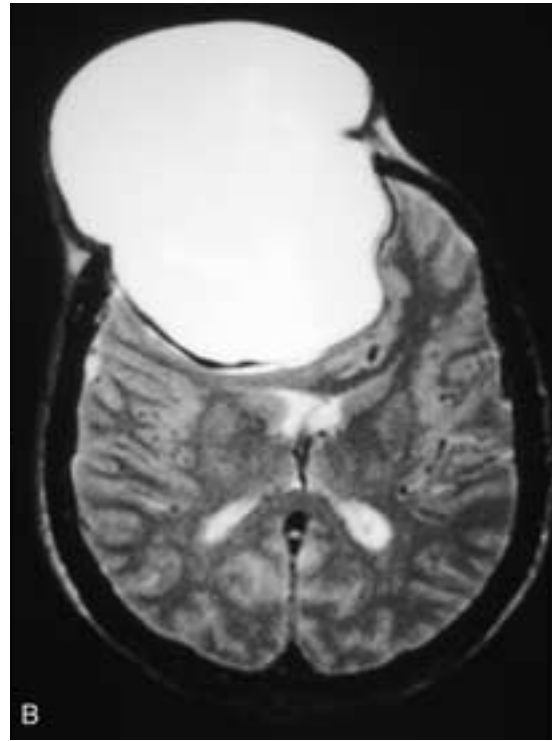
Sagittal T1-weighted (A) and axial T2-weighted (B) MR images show a huge expansile frontal sinus mass. There was no hemorrhage within this mucocele; the high signal intensity was due to the macromolecular protein concentration. (Case courtesy of Ilka Gerrero, M.D.)
